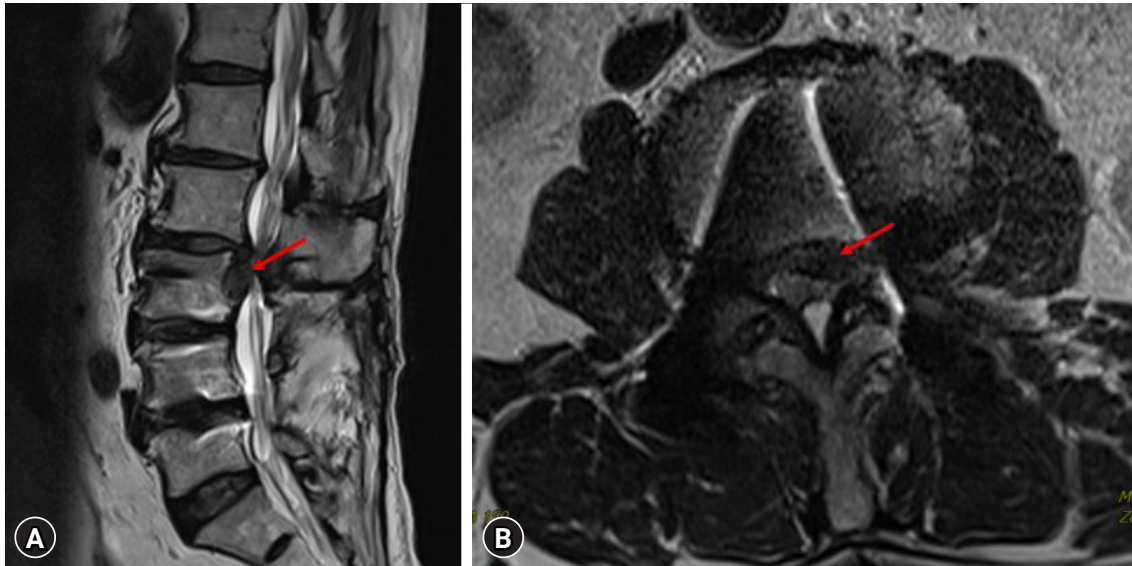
Preoperative magnetic resonance imaging sagittal view (A) and axial view (B) showing a left-sided disc herniation with inferior migration at the L2–3 level (arrows).
